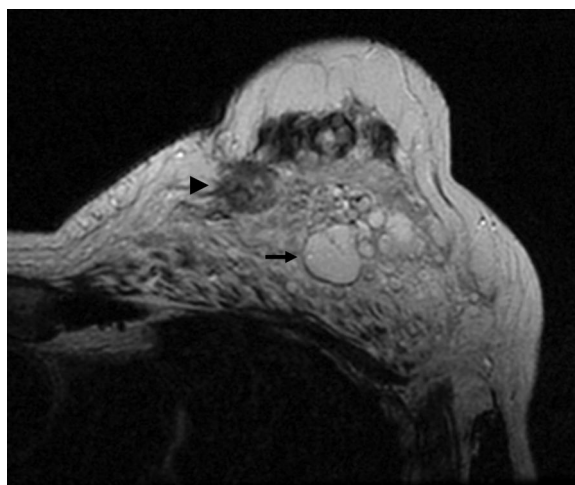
T2-weighted magnetic resonance imaging scan of a 64-year-old woman following silicone injection demonstrates high-intensity, well-circumscribed white nodules in the posterior breast (arrow) representing injected silicone. There is also an ill-defined darker mass in the anterior breast (arrowhead) suggestive of breast cancer.
